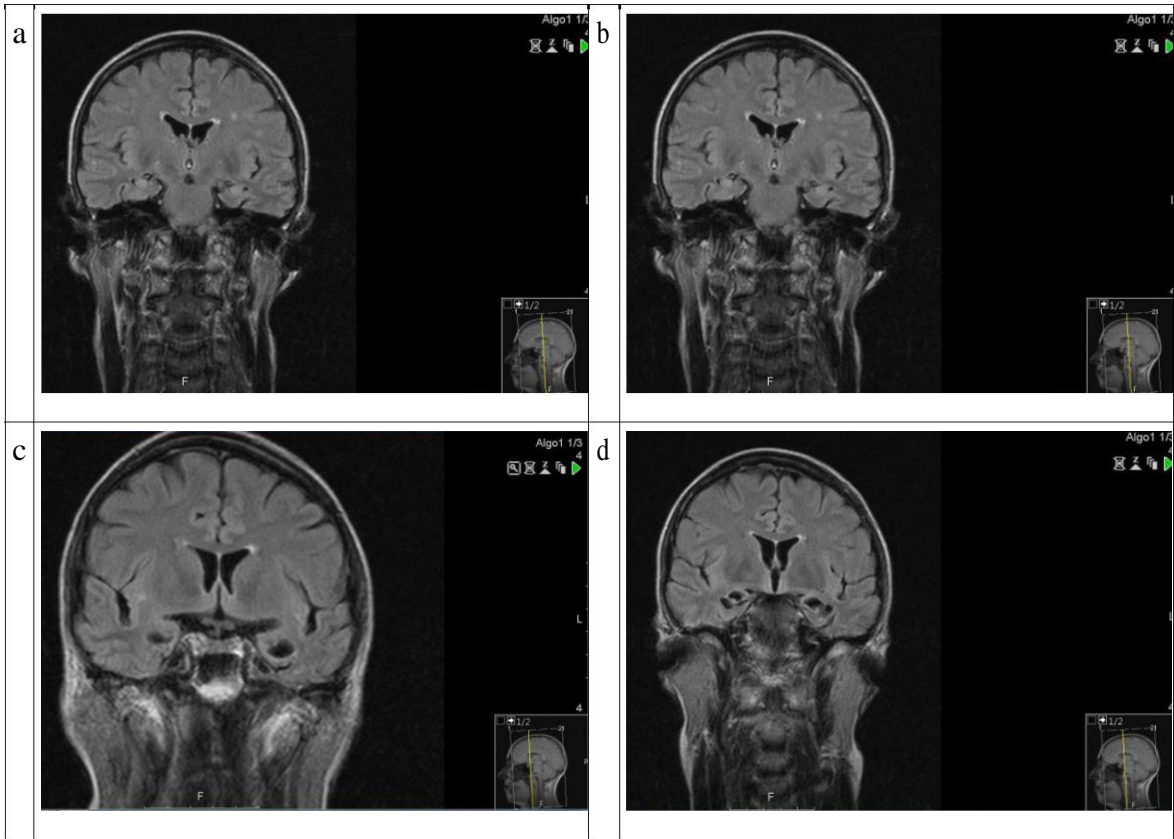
Sequence of MRI scans for Patient TC
